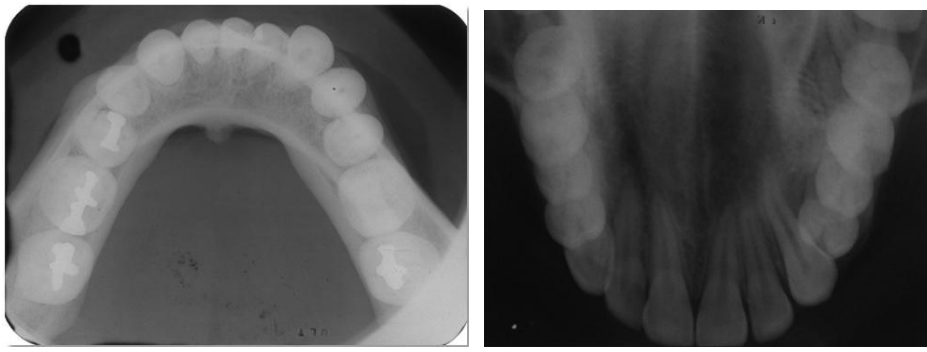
Occlusal radiograph
